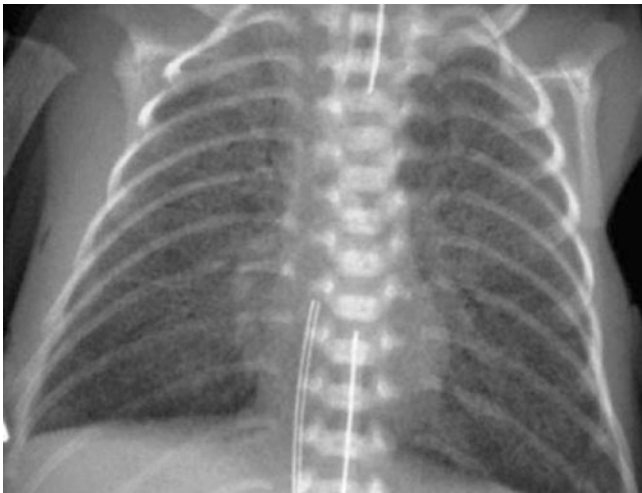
Chest radiograph of premature newborn shows a bilateral and symmetrical diffuse ground glass lung appearance with a hyperinflated thorax (due to intubation). Without intubation, the thorax typically has a low volume. In some patients, air-bronchograms can be seen. The patient has venous and arterial umbilical catheters
